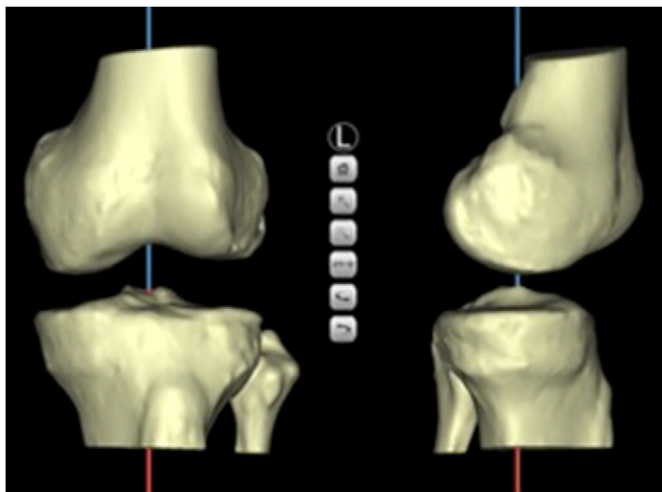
3-dimensional model of the patient's anatomy, created using magnetic resonance imaging, for templating of the optimal bony resections.
